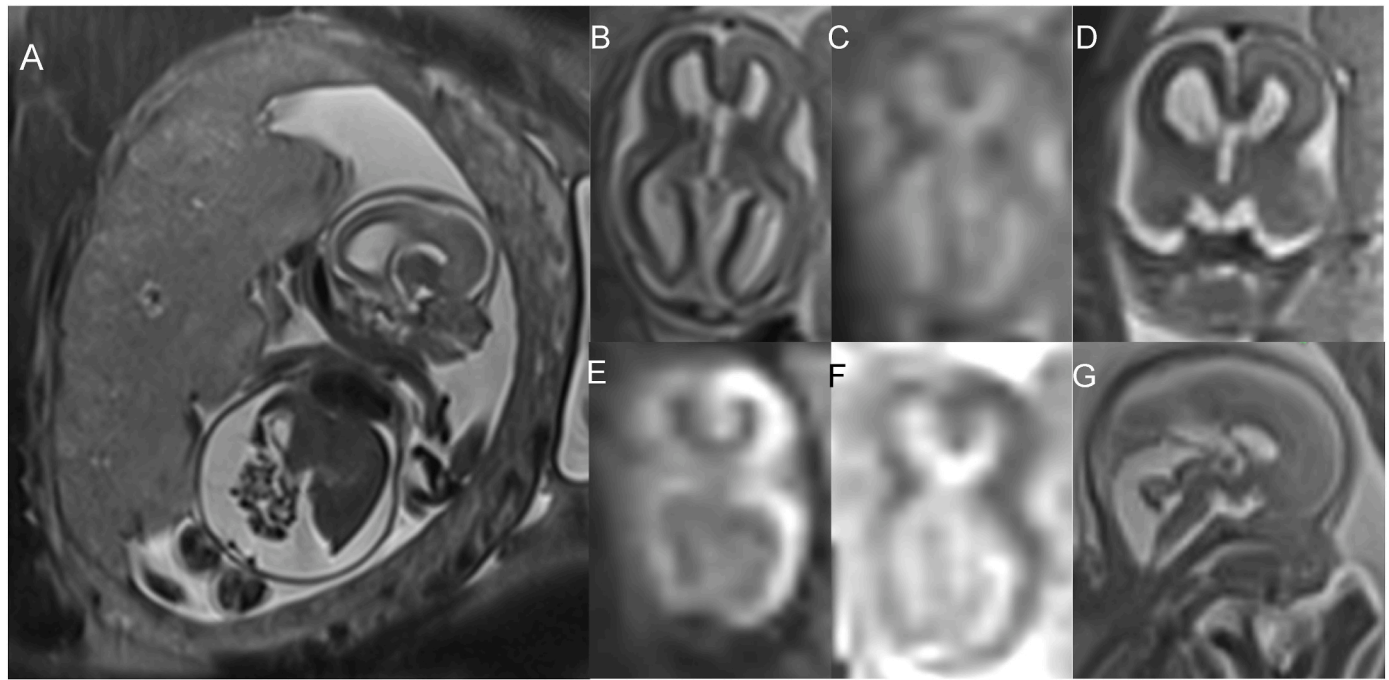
(Case 1) Fetal MRI at 20 + 2 weeks of fetus diagnosed with congenital CMV (A: coronal body showing placentomegaly, fetal ascites and hepatomegaly; B: axial T2 showing cerebral ventriculomegaly, parenchymal thinning, and abnormal signal throughout the left cerebral hemisphere; C: axial EPI showing abnormal signal in the right hemisphere; D: coronal T2 showing ventriculomegaly and abnormal signal in left hemisphere; E–F: axial DWI (E) and ADC (F) showing restricted diffusion throughout left hemisphere and parts of right hemisphere; G: sagittal T2 showing short corpus callosum and small posterior fossa structures).
